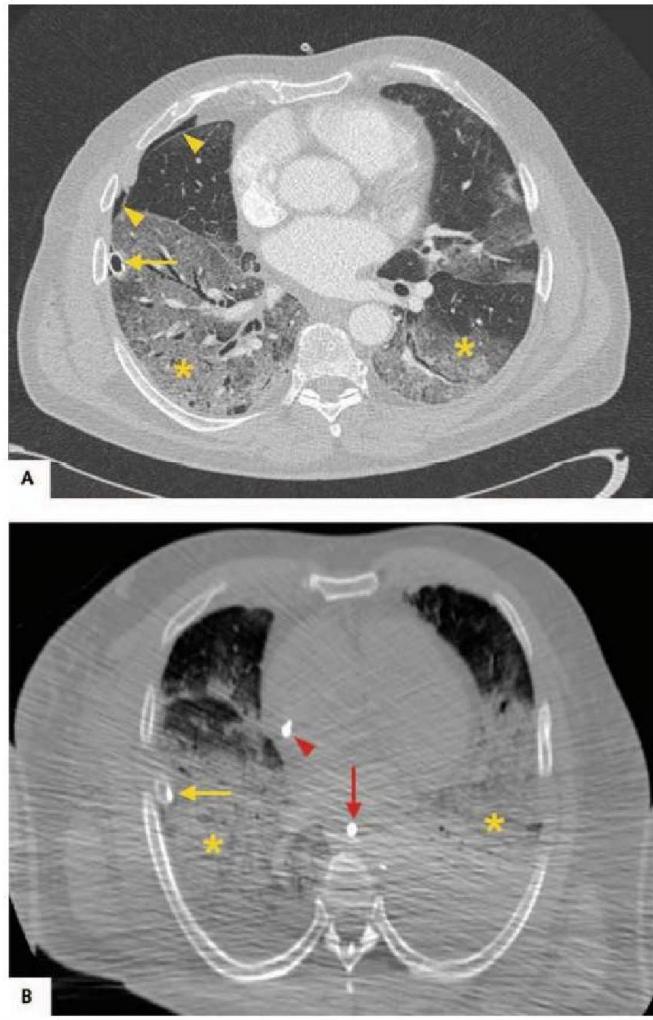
Antemortem versus postmortem computed tomography imaging (case 3).
